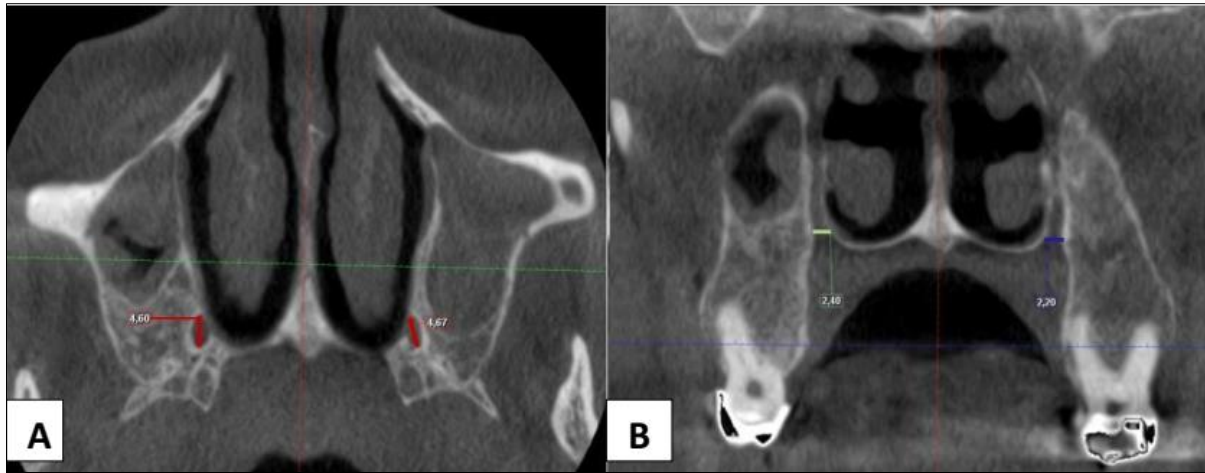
CBCT: Coronal reconstruction showing how the distance between GPF and ART was determined
